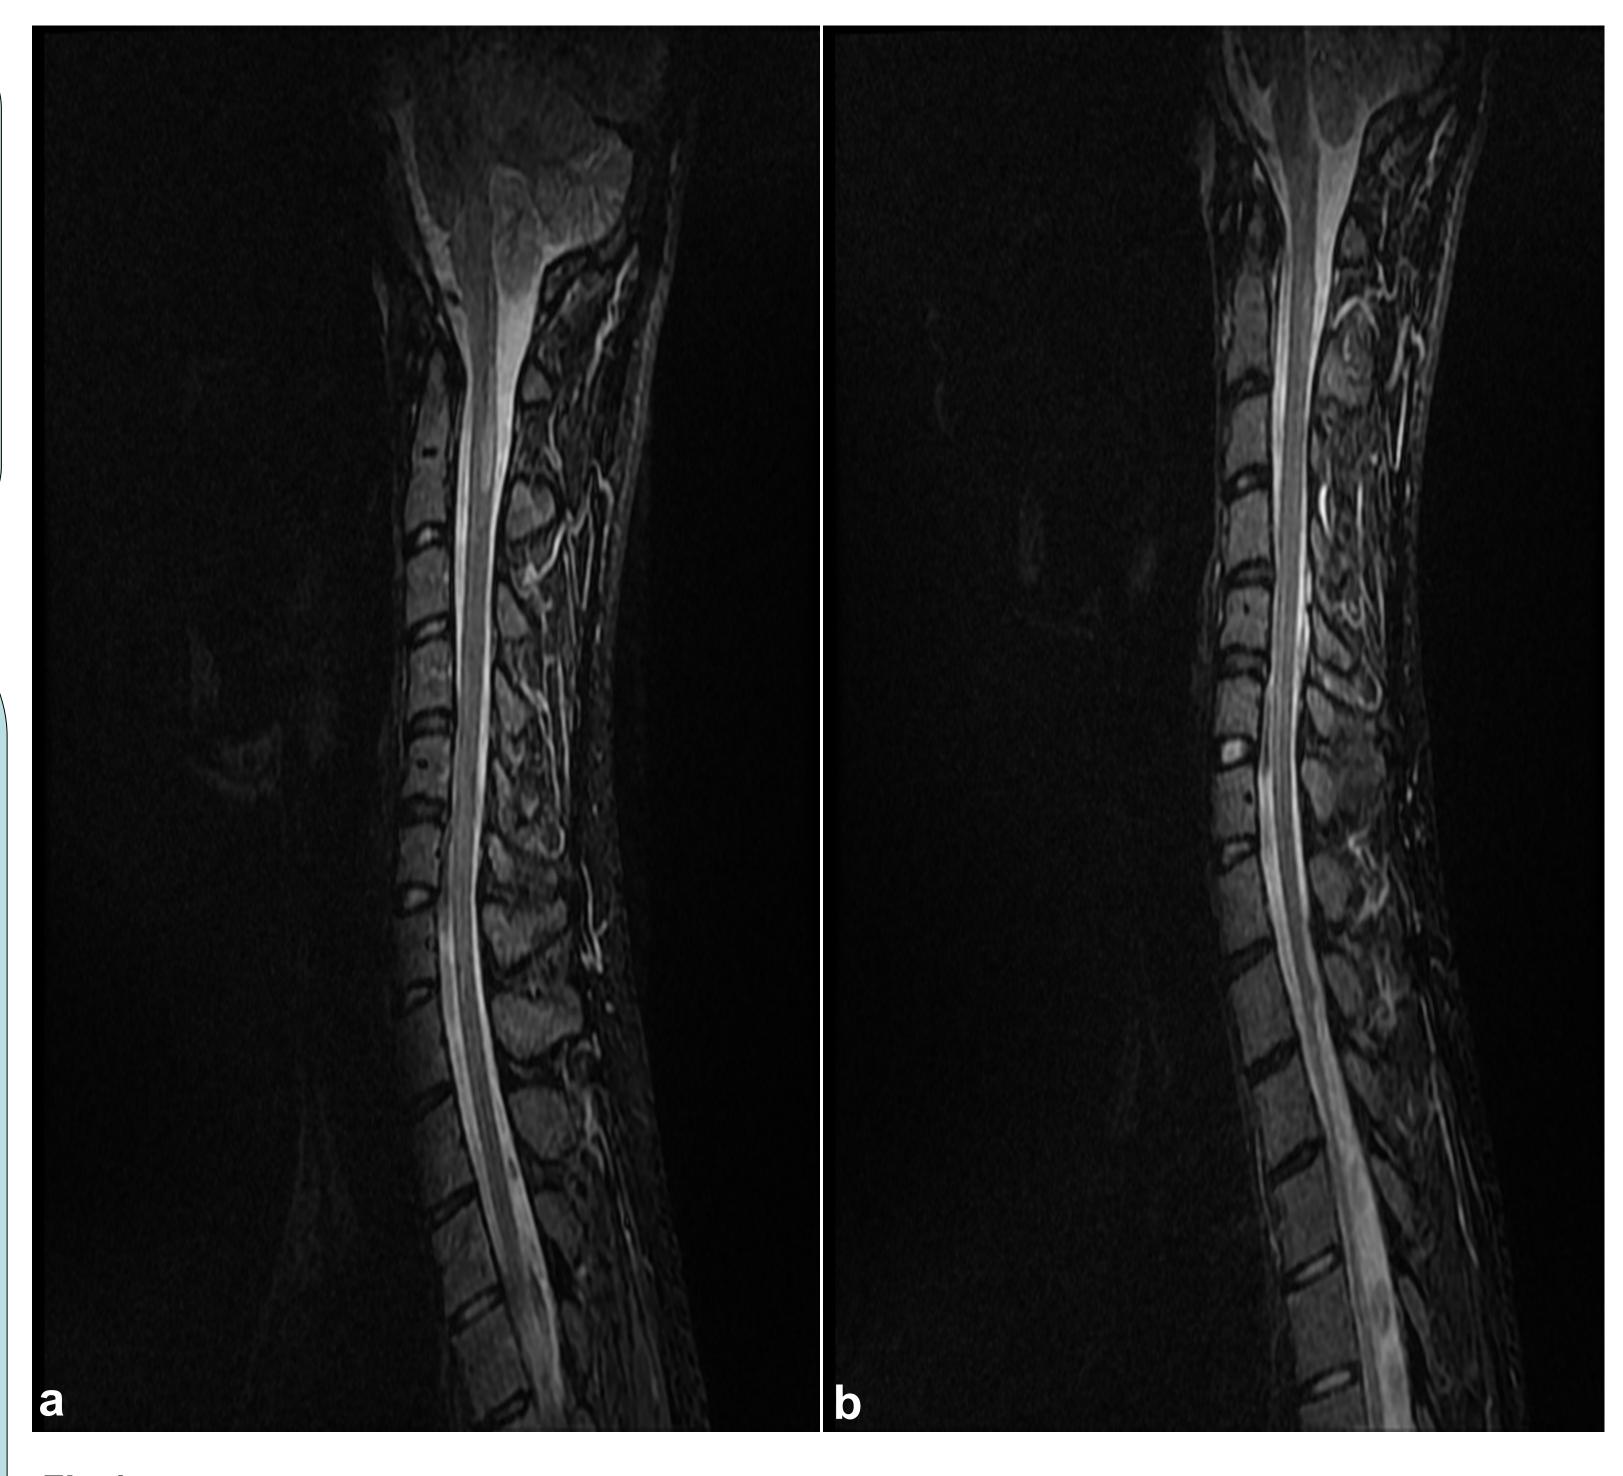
a. Cervical segment MRI (STIR sequence) showing a C1-C2 demyelinating lesion. September 2016, before tocilizumab initiation.
